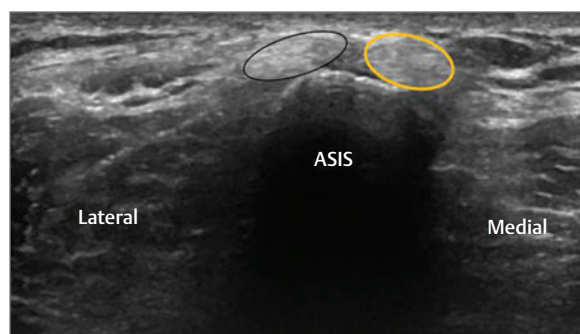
Ultrasound image of the anterior superior iliac spine (ASIS). The probe is placed transversely over the ASIS in the transverse plane. The tendons of sartorius and tensor fasciae lata share a common attachment at the ASIS. If the probe is moved distally, the two tendons can be seen to separate with sartorius directed medially (*yellow oval*) and tensor fasciae lata directed laterally (*black oval*).
